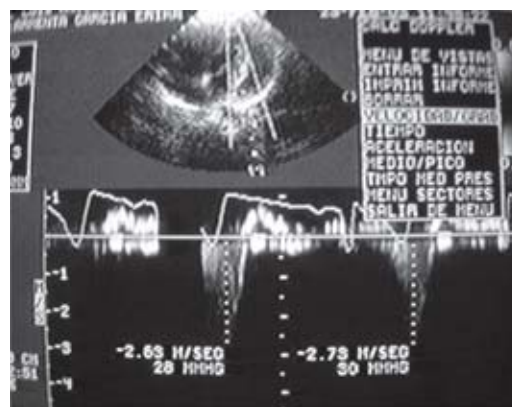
(B) Mitral valve: Doppler high frequency showed regurgitation.
